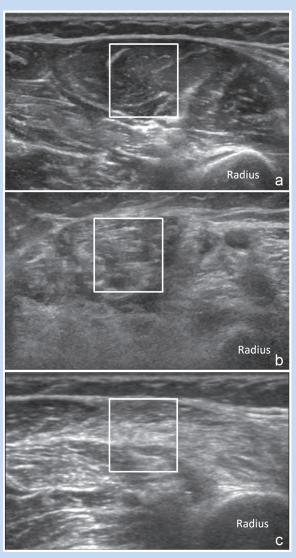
Transverse sonographic images of the forearm. Sampling of muscle images (squares) demonstrates differential muscle echogenicity in (a) a normal patient, (b) a patient with myopathy, and (c) a patient with neuropathy. Note that the superficial cortex of the radius is poorly visualized in the patient with myopathy (b), a characteristic feature.
